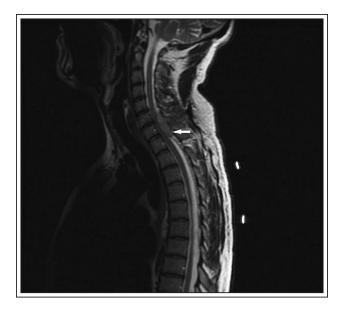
MRI of the entire spine showing a destructive cervical spinal mass (denoted by the white arrow) at the posterior aspect of the C7 vertebral body extended to the spinous process and the epidural space with mild compression of the lower cervical cord.
